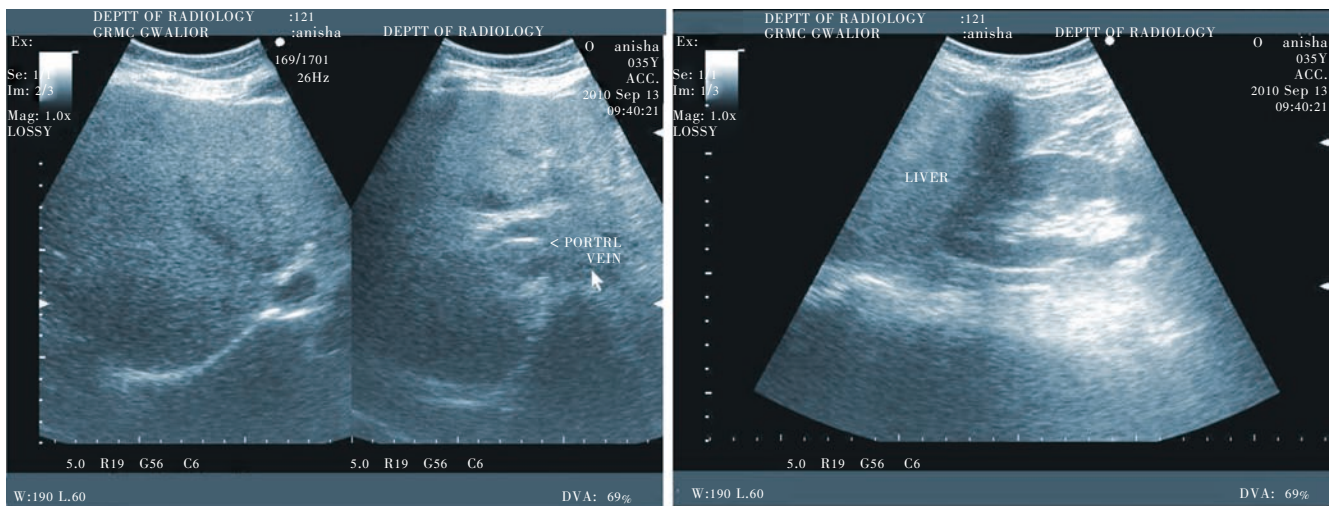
Sonogram showing increased liver echogenicity and liver–kidney contrast with blurring of peripheral portal vein margins and slight deep attenuation suggestive of grade II fatty liver.
